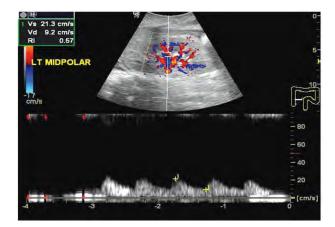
Color Doppler assessment of the left main artery and its branches in a 7 years old male boy ,biopsy proven focal global glomerulosclerosis 15% and mild interstitial fibrosis 10% later on biopsy, crescentic glomerulonephritis with 2<sup>nd</sup> focal segmental glomerulosclerosis. Grey scale showed increased renal parenchymal echogenicity.
